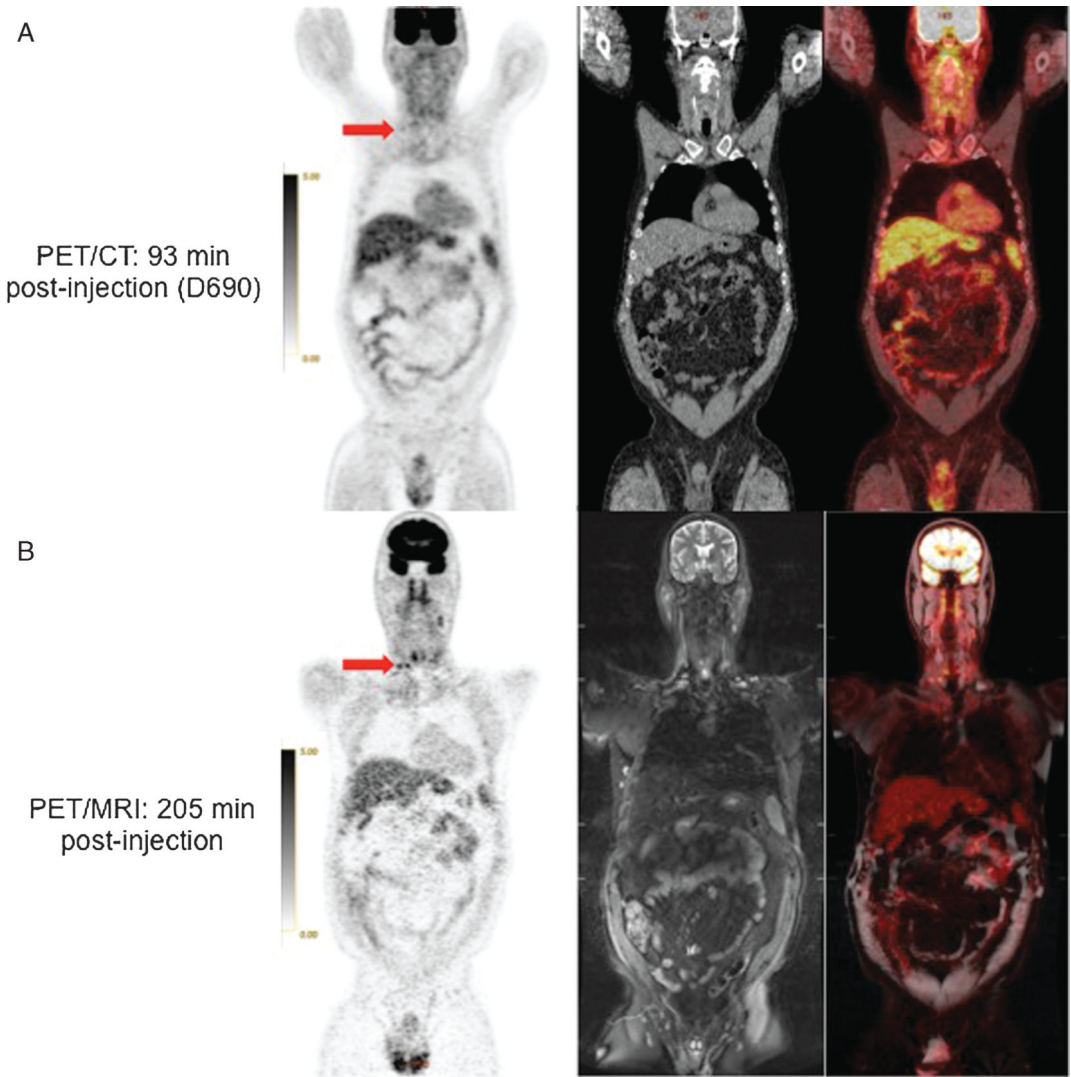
64 year-old man with CLL. ^{18}F FDG-avid cervical lymph nodes (arrows) are less conspicuous on PET from PET/CT (A) than on PET from PET/MRI (B). Corresponding coronal CT, STIR MRI and fused PET/CT and PET/MR images are also shown.
